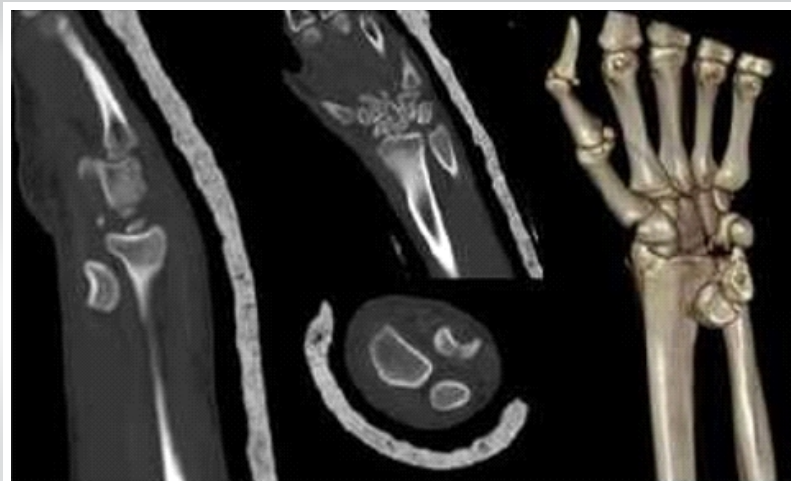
Computed tomography (CT) scan and CT reconstruction of the left wrist showing volar trans-scaphoid perilunate fracture-dislocation migrated into the forearm.
